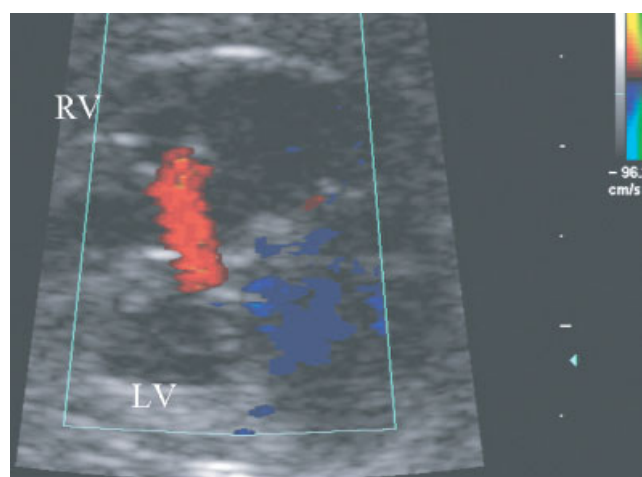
Color Doppler ultrasound image showing a small ventricular septal defect comprising the inlet part of the interventricular septum. This defect did not close spontaneously. LV, left ventricle; RV, right ventricle.
